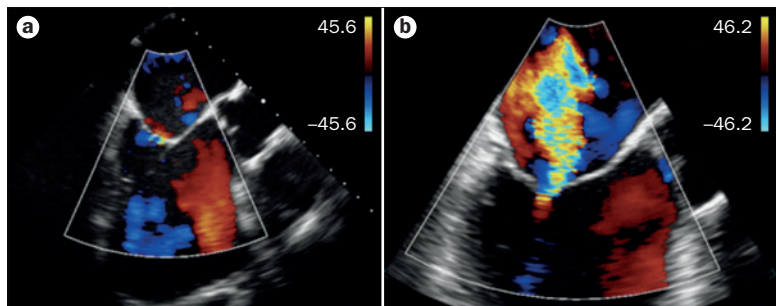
Transoesophageal Doppler echocardiogram in a patient with a clinical history of flash pulmonary oedema and fluctuating mitral regurgitation. a | Baseline measurement and b | during the Trendelenburg manoeuvre.
